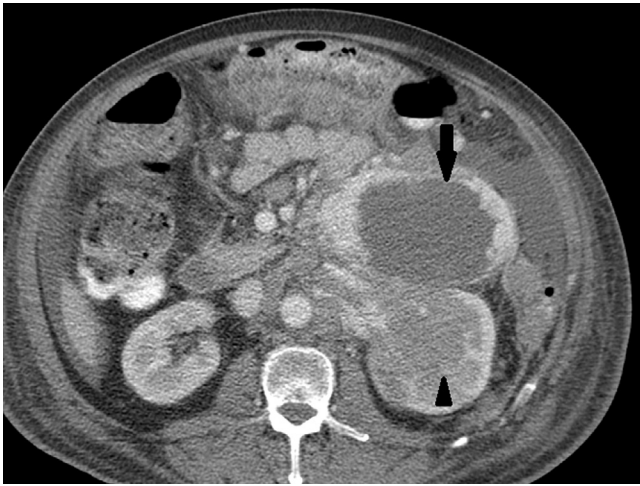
■ RCC and lymphoma. Post-contrast CT demonstrates a complex left renal mass. There is an irregular hyper-vascular mass in the upper pole of the left kidney (see arrow), as well as a poorly enhancing soft-tissue mass in the lower pole (see arrowhead). Incidental para-aortic nodes were seen. Biopsy of both components was performed, confirming the presence of a clear cell carcinoma in the upper pole and a lymphoma of the lower pole. There was no previous history of lymphoma. Following chemotherapy, the lower pole renal mass responded, as did the nodal disease. Nephrectomy was performed for the clear cell carcinoma of the upper pole.
